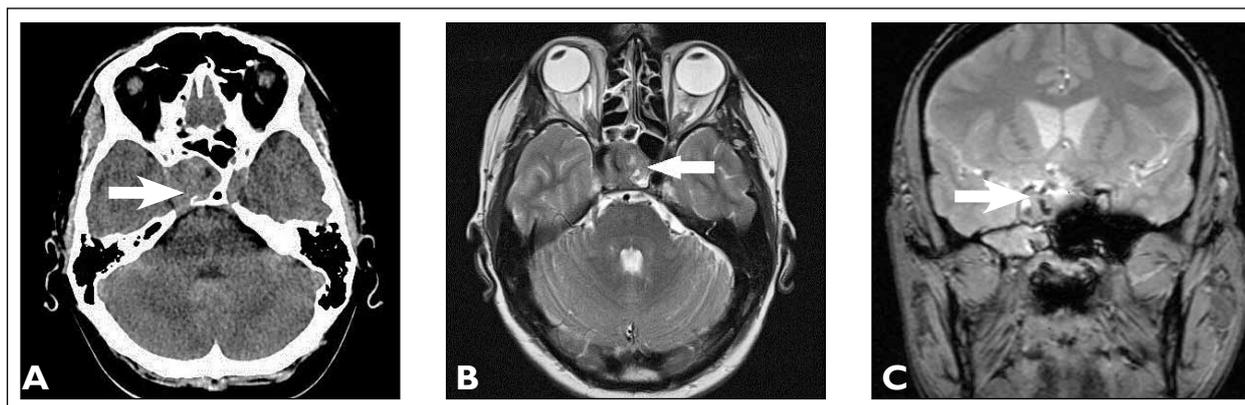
Computed tomography scan image showing the enlarged sella and the pituitary tumour. FIGURE 1B Magnetic resonance imaging (MRI) scan showing the same tumour. FIGURE 1C MRI scan showing haemorrhage within the tumour.
